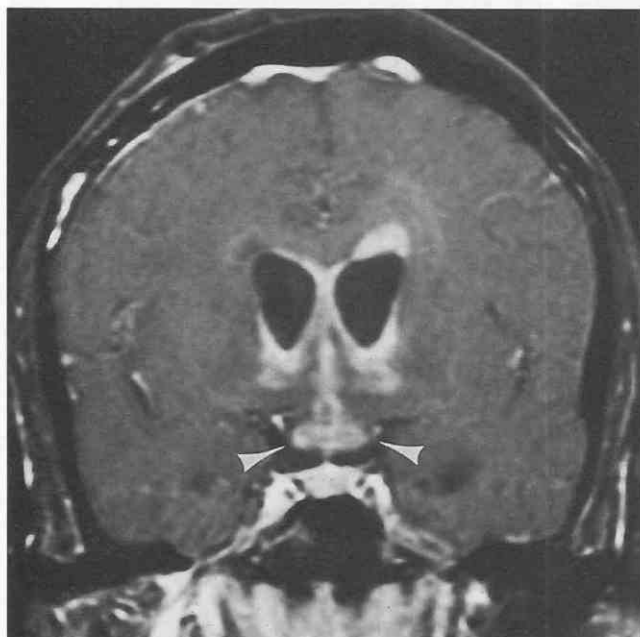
Disseminated germ cell tumor. This pineal region neoplasm demonstrates ependymal and subarachnoid spread involving the optic chiasm (arrowheads) on an enhanced coronal T1-weighted image.
